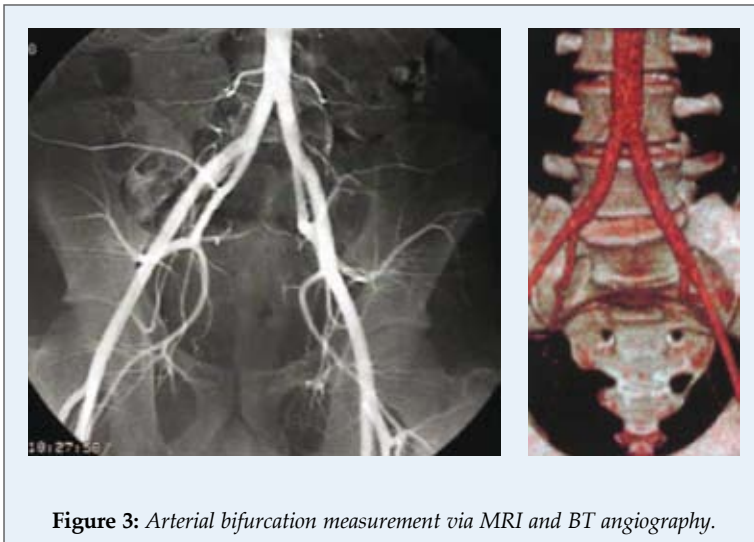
Arterial bifurcation measurement via MRI and BT angiography.
